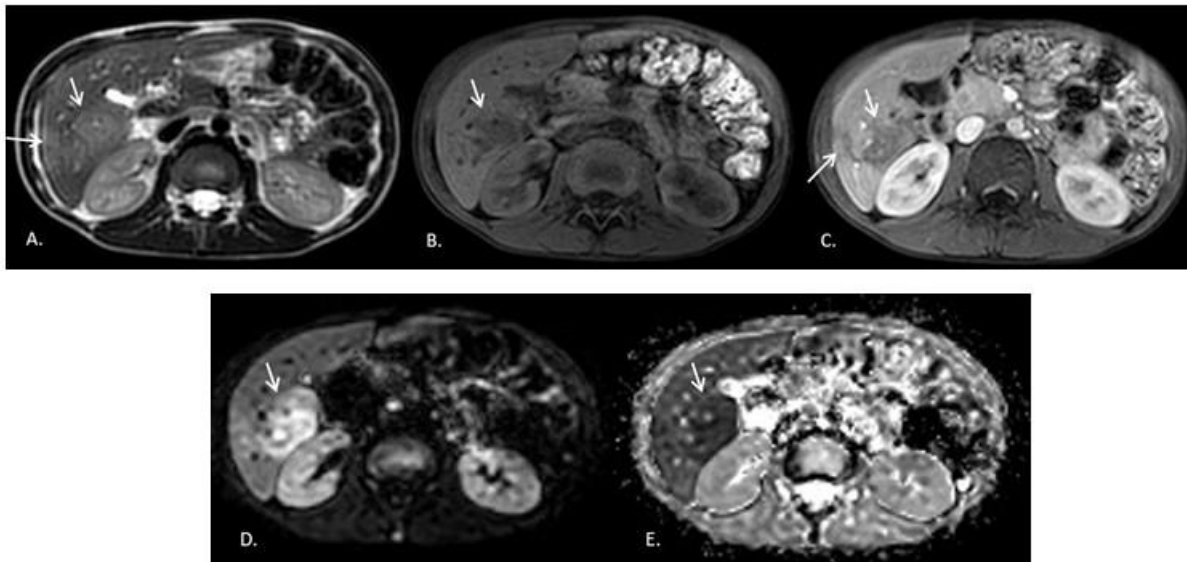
Magnetic Resonance Imaging (MRI) of liver: axial plane images show subcapsular lesions with subtle, irregular borders in the right lobe of the liver (segment 6), slightly hyperintense in T2WI (A), hypointense in T1WI (B), without significant contrast enhancement after gadolinium injection (C). The lesions show diffusion restriction according to DWI (D) and ADC map (E)
